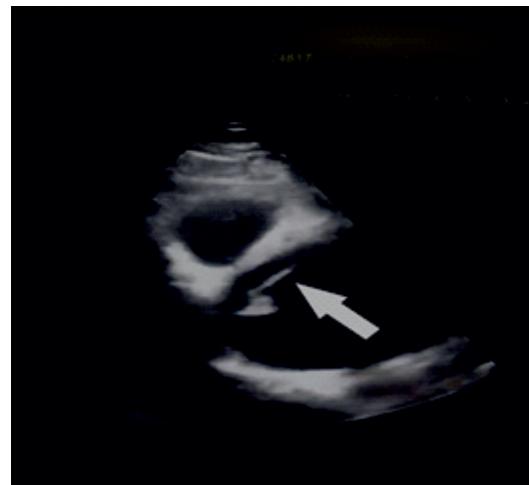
Transthoracic echocardiogram, 2D image, parasternal long-axis view showing aortic dilation and membrane dissection beginning at the aortic valve cusps.
